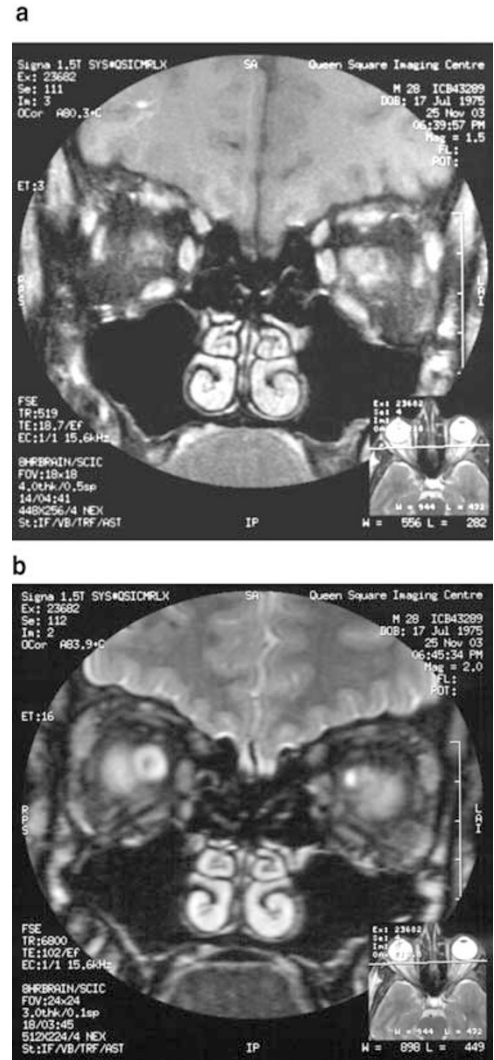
Orbital MRI scan showing dilated optic nerve sheaths and indented posterior globes in chronic papilloedema due to raised intracranial pressure.
